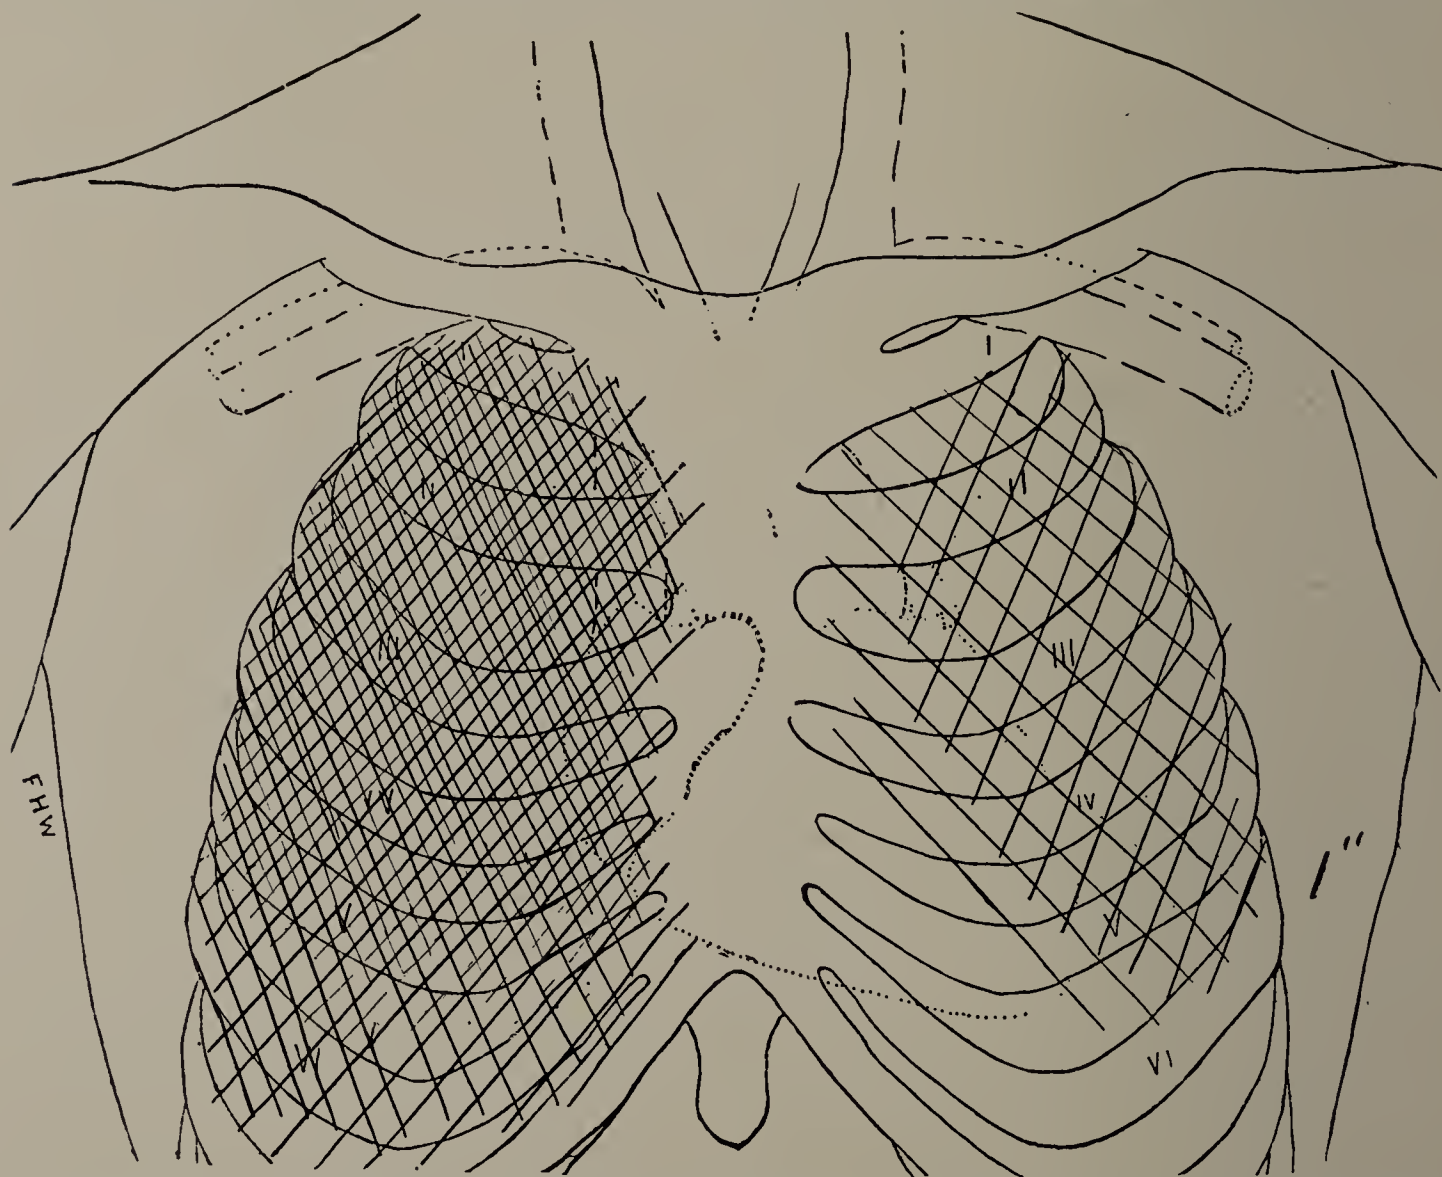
G. R. First X-ray examination with screen. Pneumonia on both sides. Diaphragm not seen on right side as the lung is too dense; excursion on left side 2.5 centimetres. (One-third life size.)
